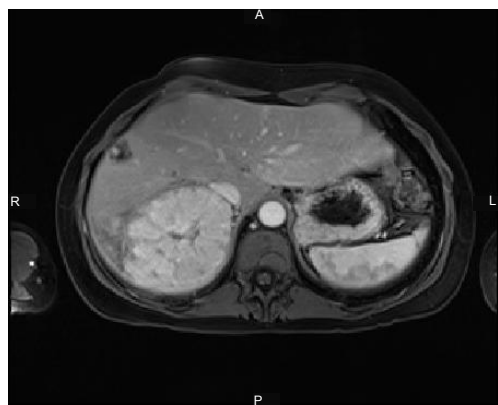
MRI. Injection of gadolinium, contrast uptake by the tumour.
